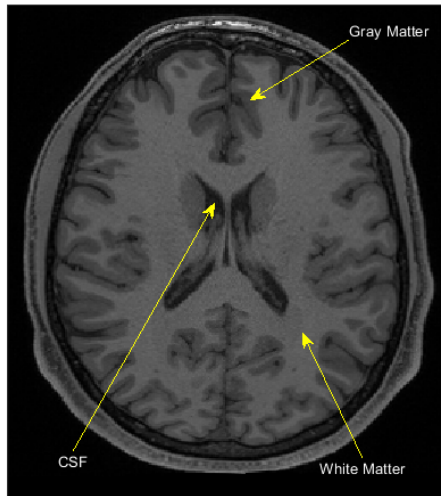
Human brain tissues can be categorized as the gray matter and white matter as depicted in gray and almost-white colors respectively. The cerebrospinal fluid (CSF) is the dark area that circles around the brain between the brain tissues and the skull. This T₁ image was obtained from an MRI from dataset in (Glasser et al., 2013).
